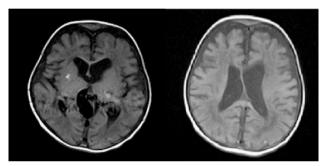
MRI Axial T1WI- Showing ill-defined hypointense areas in bilateral cerebral white matter and periventricular white matter, hyperintense soft calcification in the right lentiform nucleus
